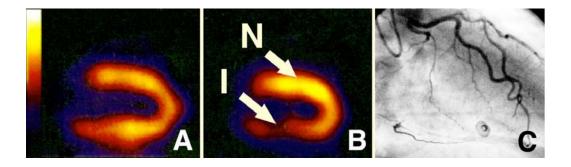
Example of selected areas for biopsies. (A) Myocardial SPECT perfusion imaging, vertical long axis section, rest image: no perfusion defect. (B) Same section, stress image with perfusion defect. Arrows show the selected areas for the reversibly ischemic (I) and control non-ischemic (N) biopsies. (C) Coronary angiography in the same patient shows filling of the occluded distal right coronary artery via collaterals, explaining the stress-induced ischemia I and confirming no stenosis in the artery to the N area.
